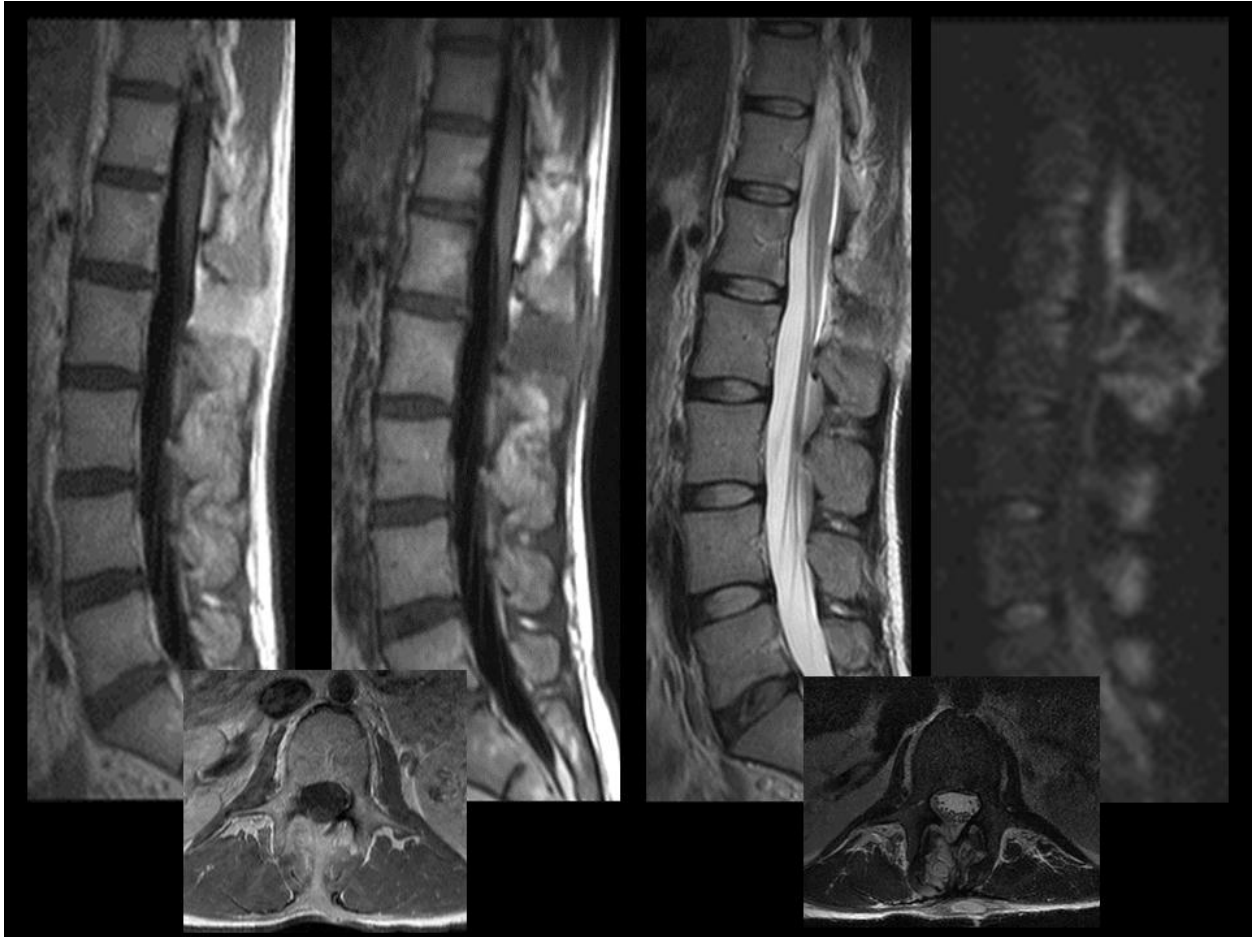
Treated osteomyelitis. From left: T1 FLAIR, contrast enhanced T1 FLAIR, T2, DWI. Inset: Axial T1 post contrast (left) and T2. Same case as previous figure. Note the absence of continued diffusion restricted after surgical and antibiotic therapy.
